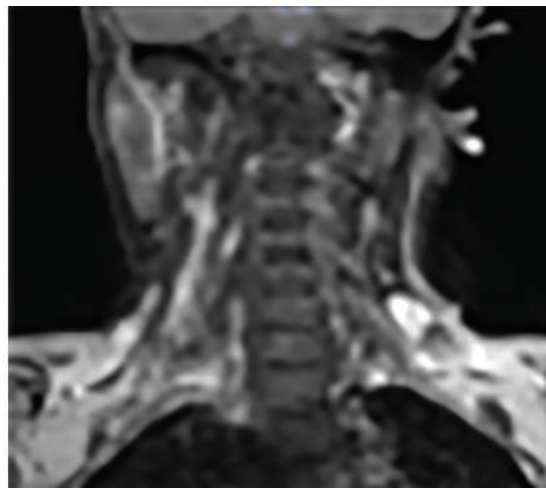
Level 5 lap image on neck MRI.
